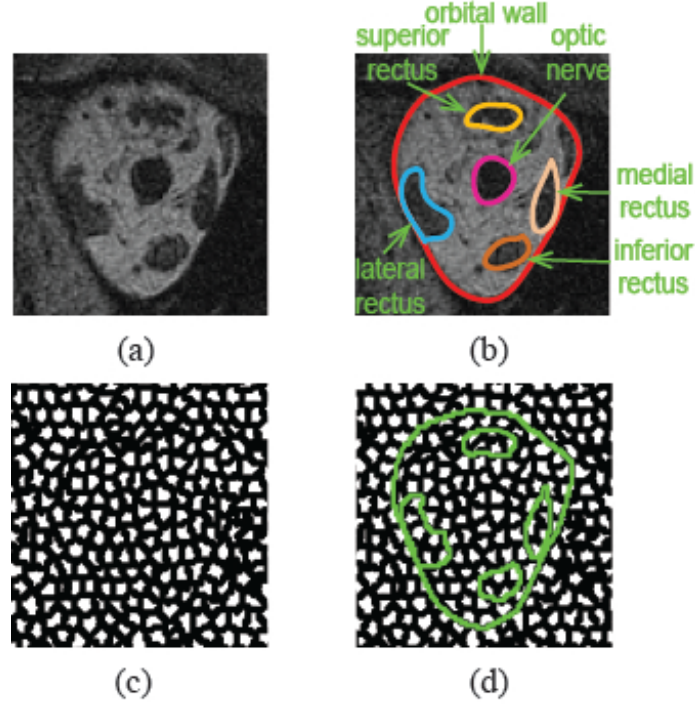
EOM anatomy in MR imaging and superpixel. (a) A representative coronal MRI image of the eyeball and EOMs; (b) Labeled ocular structures to segment, including orbital wall (red), superior rectus muscle (orange), lateral rectus muscle (sky blue), inferior rectus muscle (bright yellow), medial rectus muscle (pink), optic nerve (purple); (c) Superpixel over-segmentation; (d) Manually segmented structured overlaid on the superpixels.
